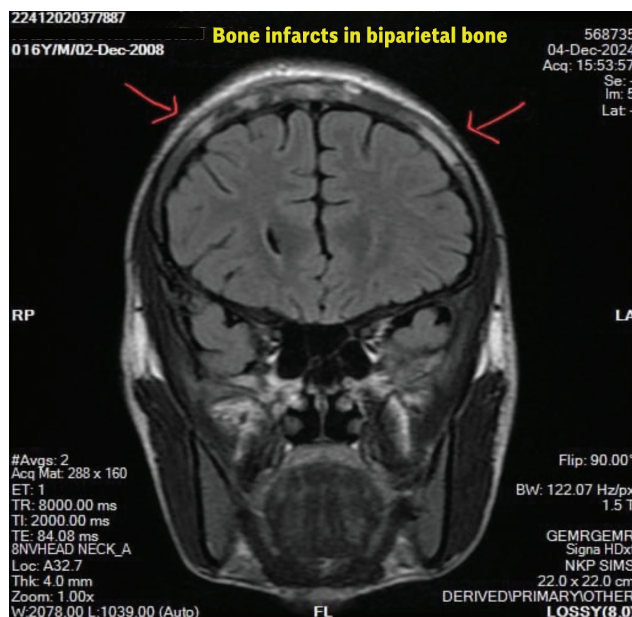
MRI brain with contrast showing bone infarcts in bilateral parietal bone
